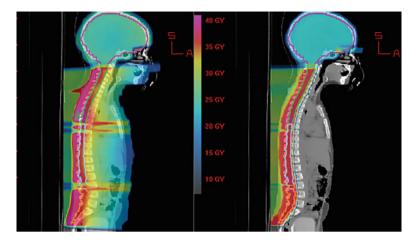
Comparison of dose distribution using X-rays (*left*) and protons (*right*) in the irradiation of the craniospinal axis and posterior fossa for the treatment of medulloblastoma in a 3-year-old child. Note the substantial reduction in the dose to the vertebral bodies, and virtual elimination of the exit dose through the chest, abdomen, and pelvis
